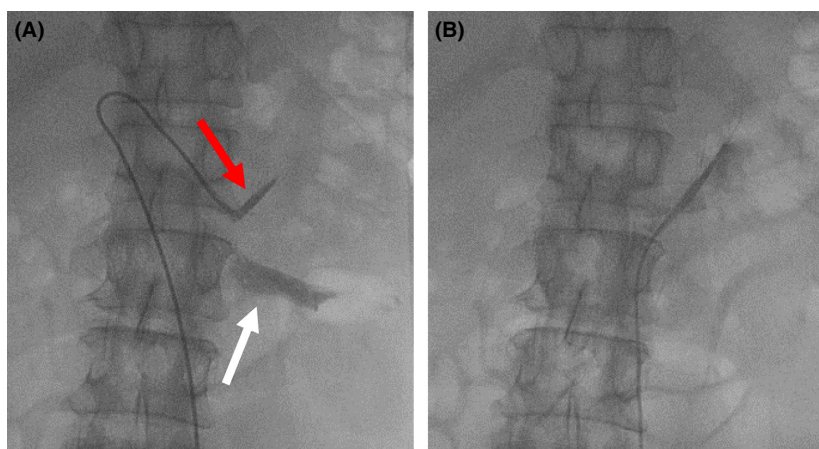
Panel A shows the left adrenal vein could be cannulated (red arrow) at a point close to the center of the left renal vein (white arrow) using CT guidance. Because the catheter was wedged, requiring a change in catheter to obtain a blood sample (B).
